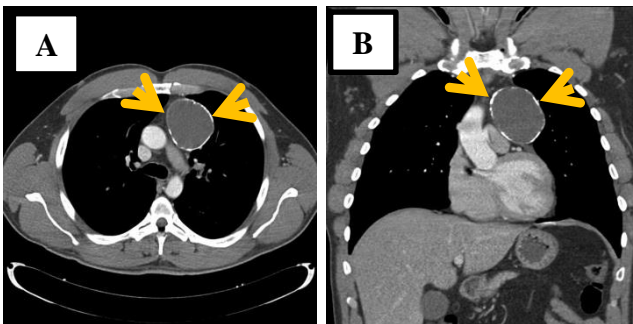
Computed tomography of ADC of the thymus. Adopted from (Moser, Schiefer et al. 2015).
